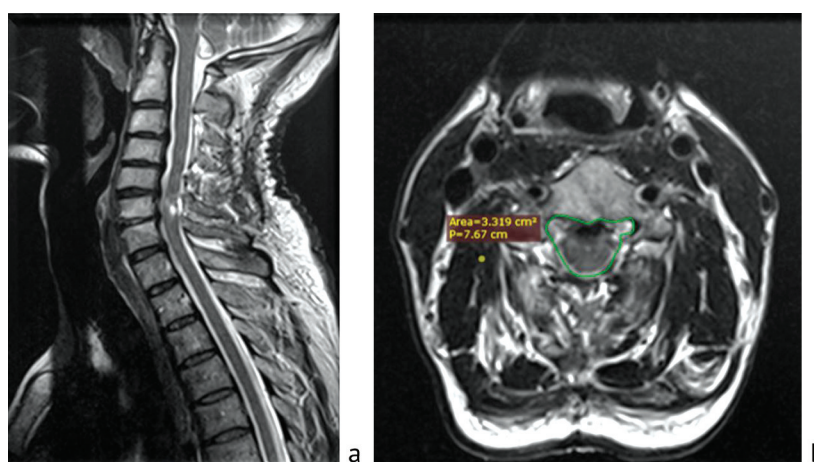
MRI of the patient's cervical spine after surgery at the level of C3-C6 vertebrae: a sagittal view; b axial view
